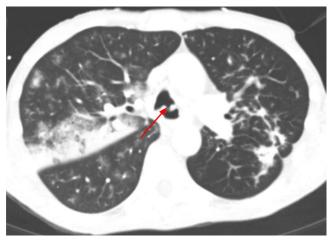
Patient is status post esophageal stent removal. Axial CT demonstrates a tracheoesophageal fistula (red arrow).
